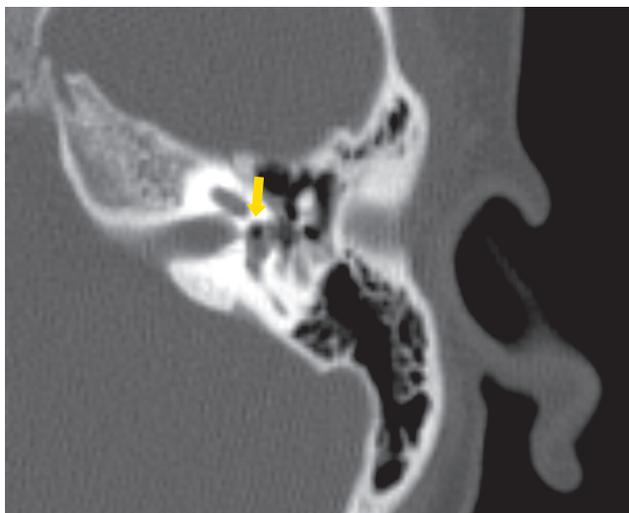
Axial computed tomography image of the temporal bone showing an air bubble in the left vestibule (arrow)
